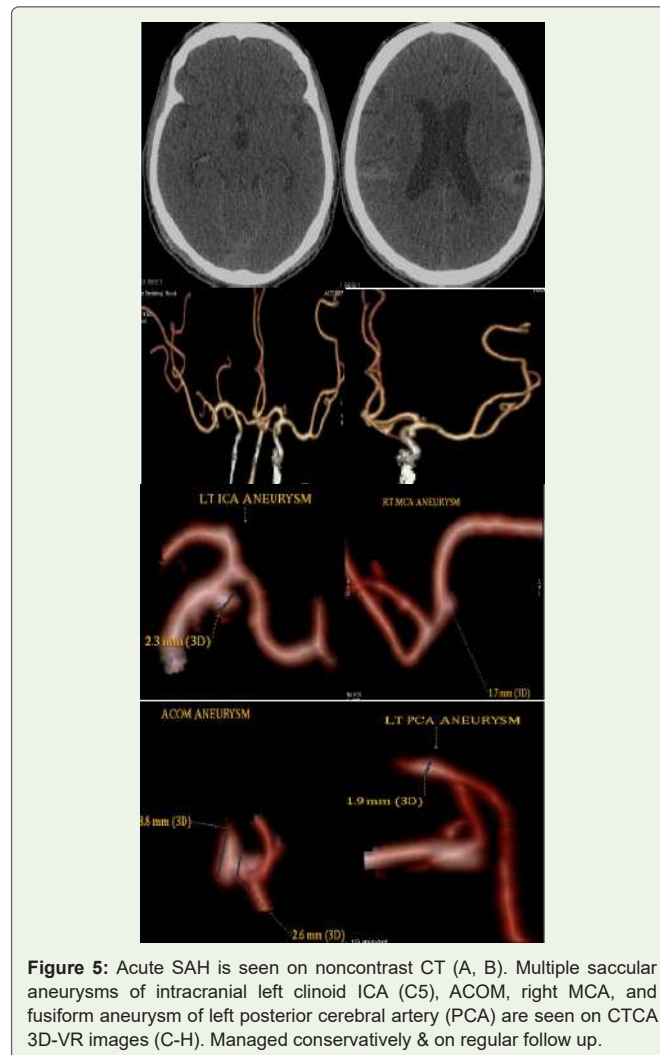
Acute SAH is seen on noncontrast CT (A, B). Multiple saccular aneurysms of intracranial left clinoid ICA (C5), ACOM, right MCA, and fusiform aneurysm of left posterior cerebral artery (PCA) are seen on CTCA 3D-VR images (C-H). Managed conservatively & on regular follow up.
